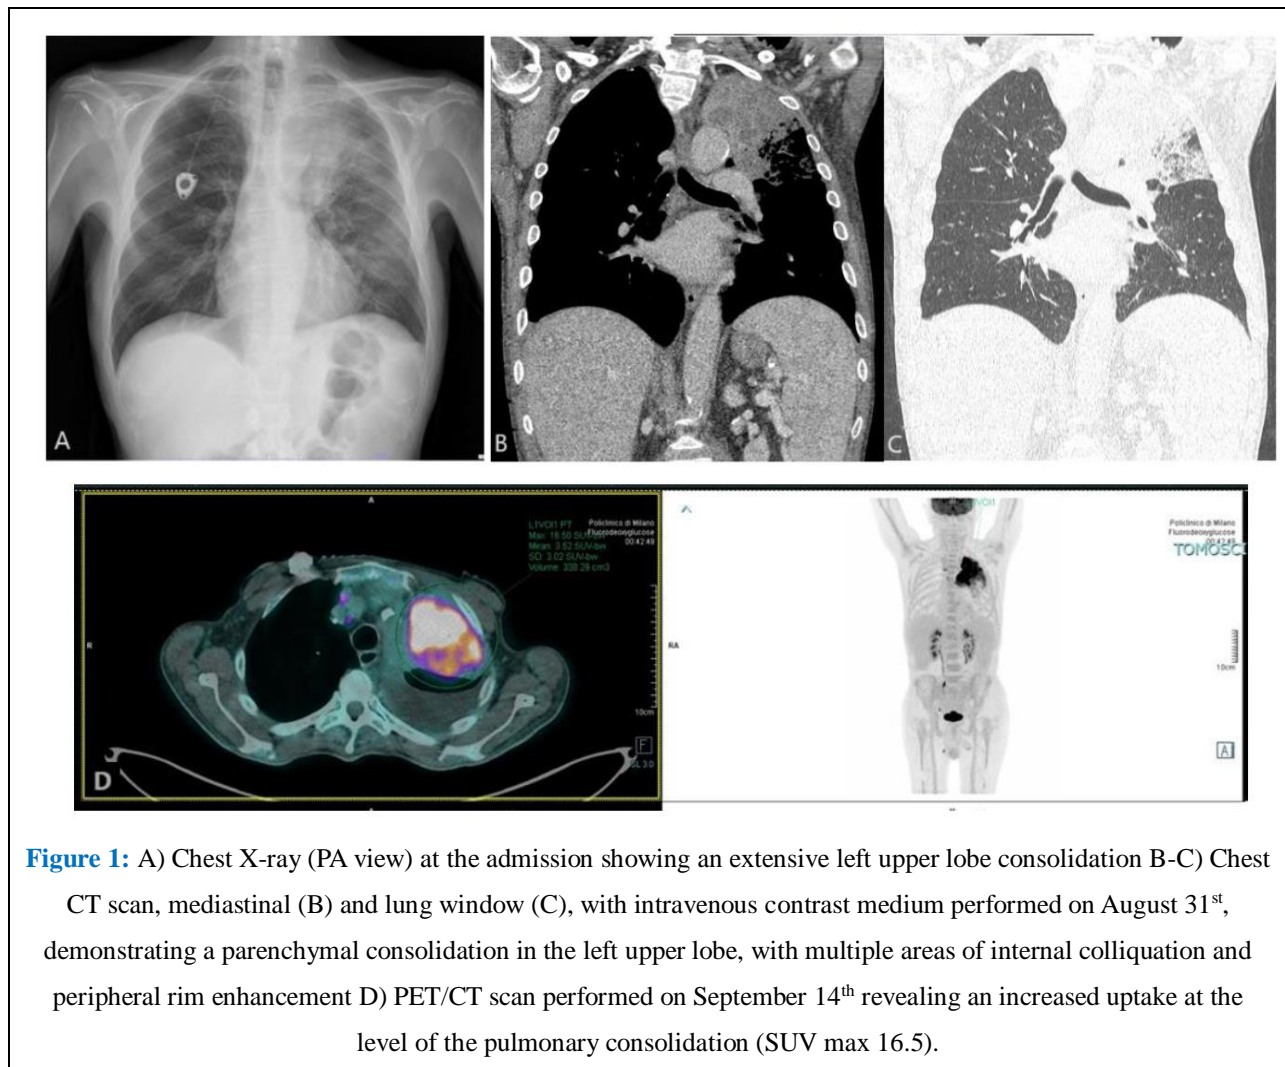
A) Chest X-ray (PA view) at the admission showing an extensive left upper lobe consolidation B-C) Chest CT scan, mediastinal (B) and lung window (C), with intravenous contrast medium performed on August 31st, demonstrating a parenchymal consolidation in the left upper lobe, with multiple areas of internal colliquation and peripheral rim enhancement D) PET/CT scan performed on September 14th revealing an increased uptake at the level of the pulmonary consolidation (SUV max 16.5).
